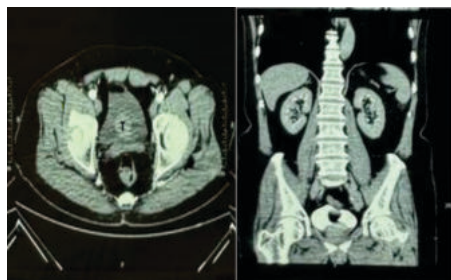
Axial view of CT Urography (image 1) showing well defined solid mass lesion (T) arising from posterior wall of urinary bladder. Coronal view (image 2) of excretory phase showing bladder mass with bilateral normal excretory kidneys.
